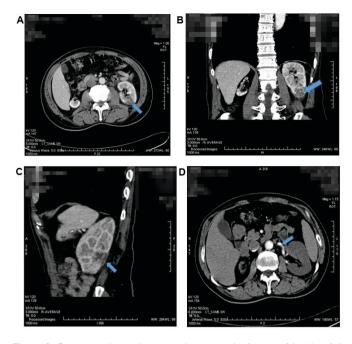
Contrast-enhanced computed tomography image with (A) axial, (B) coronal and parasagittal scanning, showing (C) multiple low-density perfusion changes among the left renal parenchyma and (D) severe stenosis of the left renal artery (arrows). Atrophy in the right kidney was also visualized.
